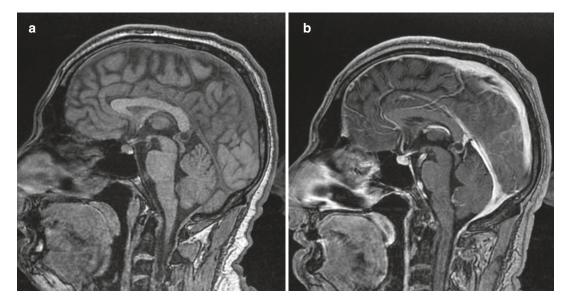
(a, b) Sagittal T1 and T1+ contrast MRI sequences in a 30-year-old male with nonspecific headache. The cyst presents a peripheral contrast enhancement that is stable in size at 1-year follow-up (b).
